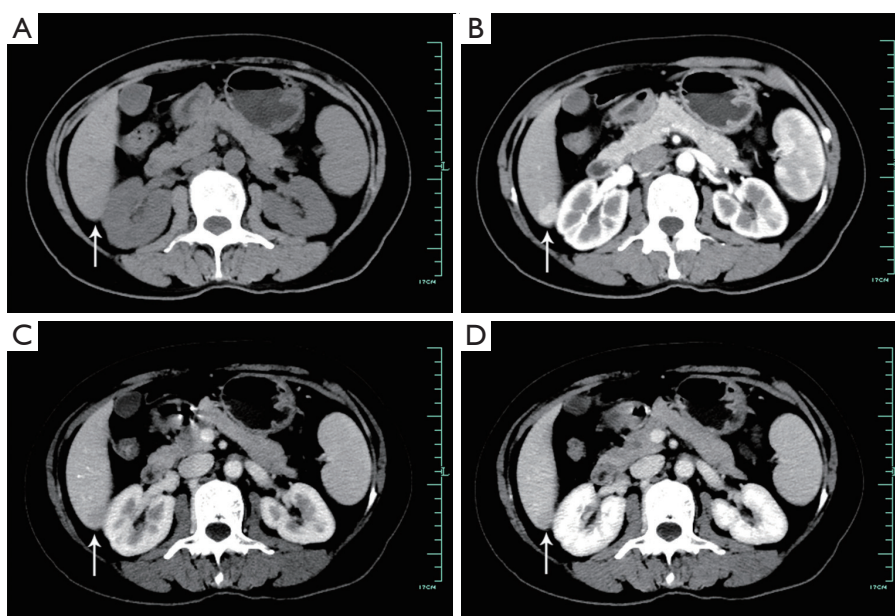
A 57-year-old female with an accidental hepatic nodule (arrow). (A) A plain CT scan shows an ill-defined nodule in the right lobe. (B) The nodule shows marked enhancement during the arterial phase. (C,D) The mass washed out during the portal phase and delayed phase.
